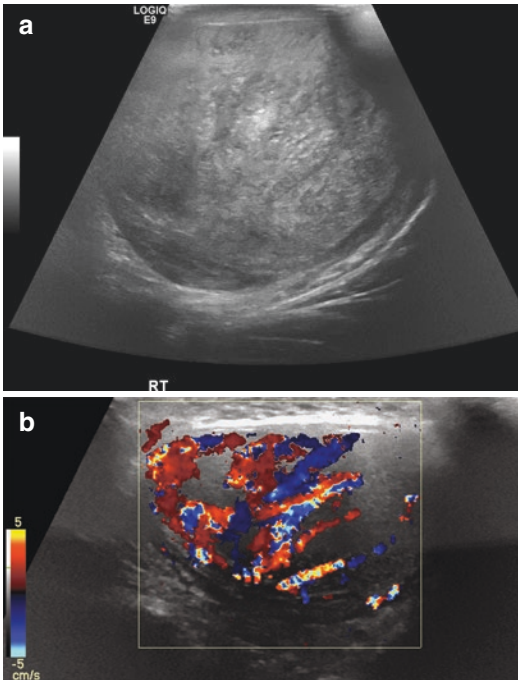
(a, b) Colour Doppler interrogation allows characterisation of this para-testicular mass as a solid lesion (rhabdomyosarcoma) rather than, for instance, a heterogeneous haematoma
